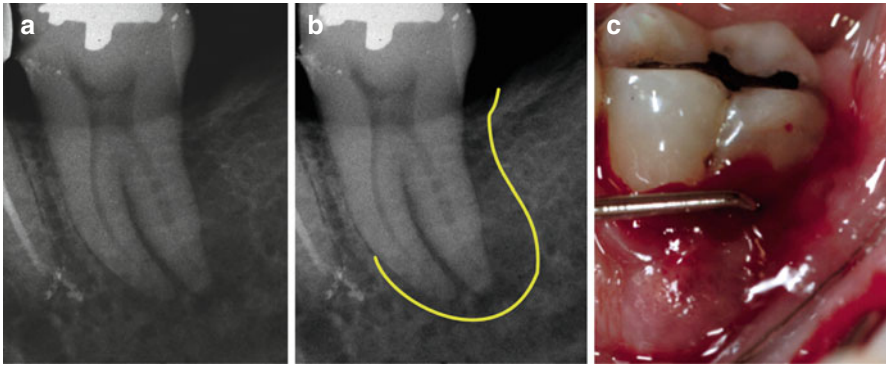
(a) Periradicular radiograph of a mandibular second molar. (b) Periradicular radiograph of the same tooth with a “J-shaped” radiolucency outlined in yellow. (c) Clinical photograph of the same tooth showing deep, narrow-based probing
